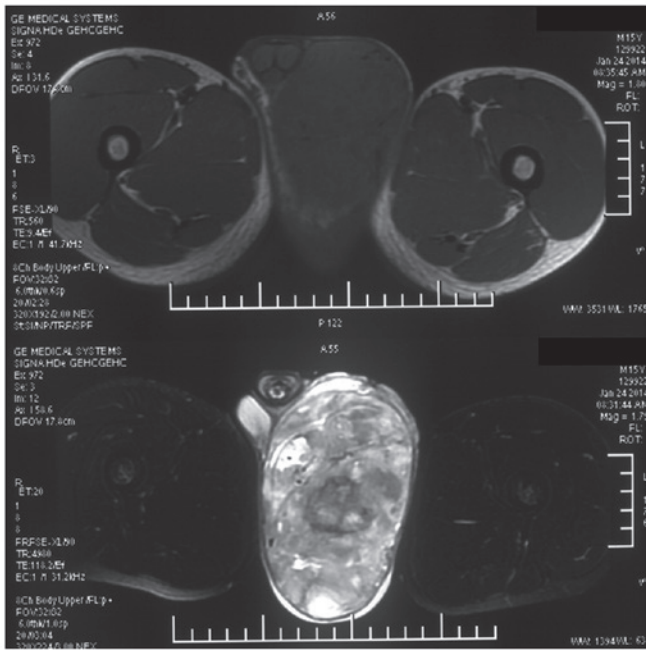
Magnetic resonance imaging scan demonstrating a left scrotal mass with a mixed signal, consisting of isointensity on T1-weighted images and high signal on T2-weighted images, with no abnormal signal identified in the right testicle and epididymis.
